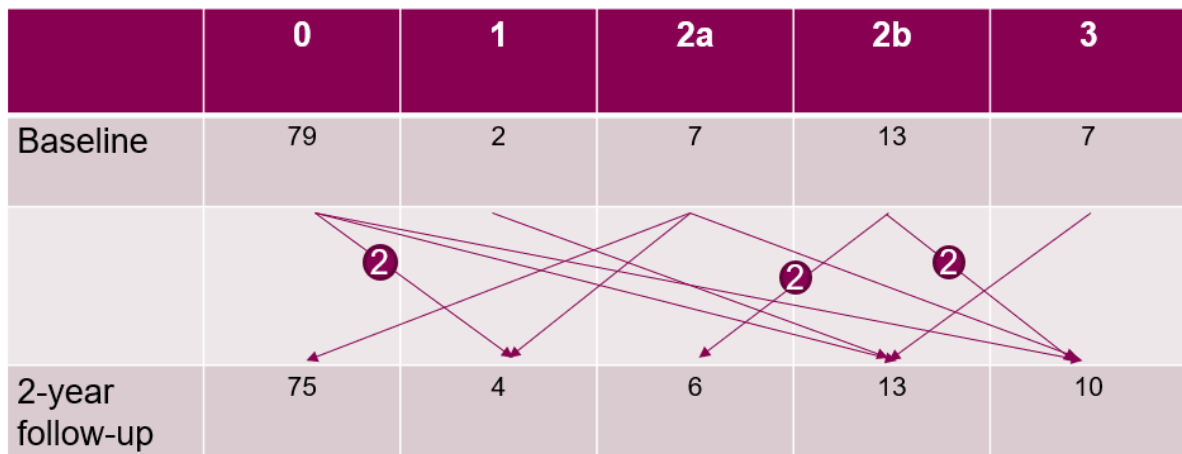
Flow-chart showing the change over time in grading of TMJ deformities (0, 1, 2a, 2b, 3) evaluated on CBCT. Data presented on joint level, an arrow representing one joint unless specified with a number.
